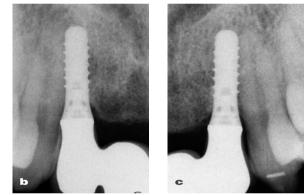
Final clinical and radiographic images of a four-unit FDP supported by two regular-neck implants at the lateral incisor sites. The frontal view in centric occlusion (a) reveals an overall acceptable result from an esthetic point of view. Note, however, the negative impact of the implant platform diameter on the line of emergence of the crowns at the lateral incisors, as well as the papillary tissue loss at the embrasure of the central incisors. The corresponding radiographs (b and c) confirm stable peri-implant bone levels and adequate marginal adaptation of the metal-ceramic implant-supported crowns.
